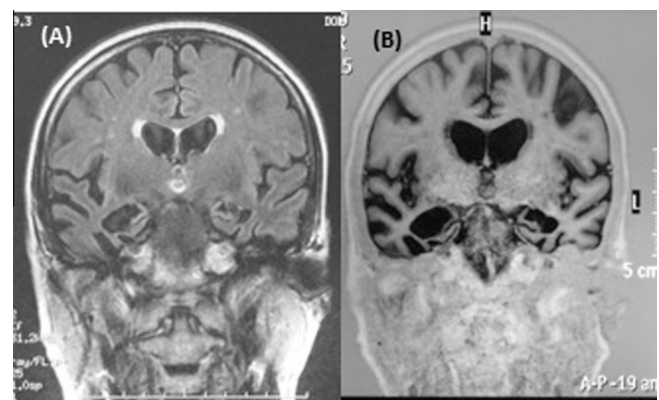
Patient 2 cranial MRI revealing clear signs of predominantly right-sided temporal atrophy. The images correspond to different stages of the disease. The image on the right (B), taken more recently, shows signs of temporal atrophy that are bilateral but noticeably asymmetrical. We observe that the MRI for Patient 1 shows more severe frontal atrophy with less pronounced hemispheric asymmetry. (A) coronal, fluid-attenuated inversion recovery (B) coronal, T1-weighted.
